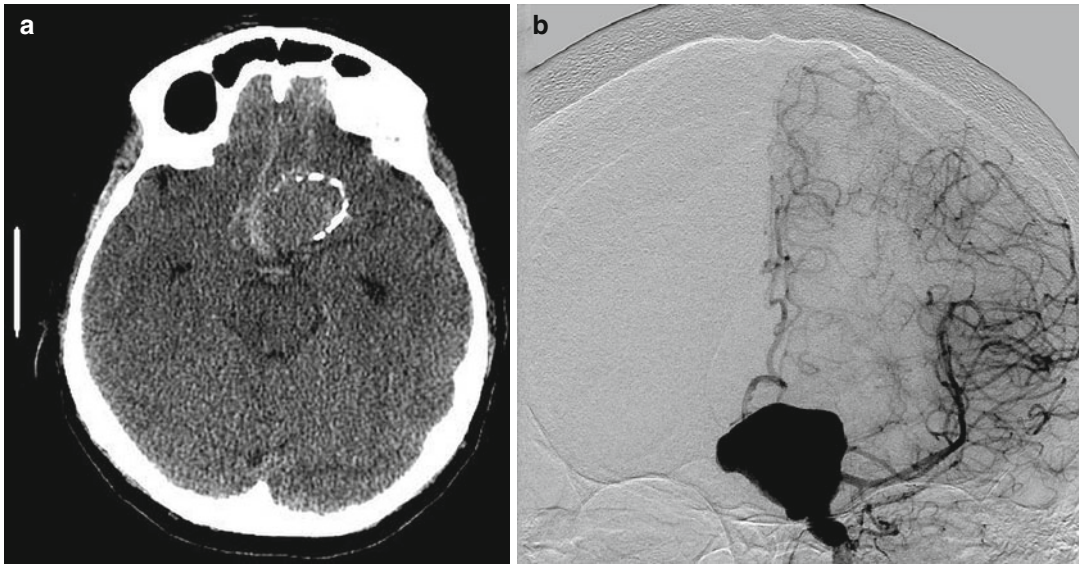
(a) CT scan demonstrates a giant carotid aneurysm with sellar/suprasellar extension. Calcification is demonstrated on the aneurysm wall. (b) Carotid angiography shows a giant superior hypophysial artery aneurysm
